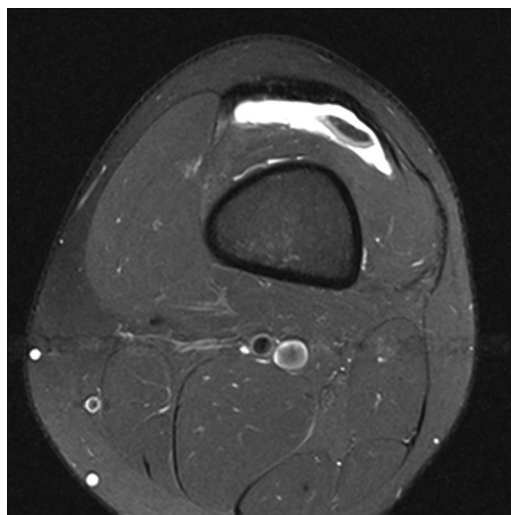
Magnetic resonance imaging of loose cartilage body.
